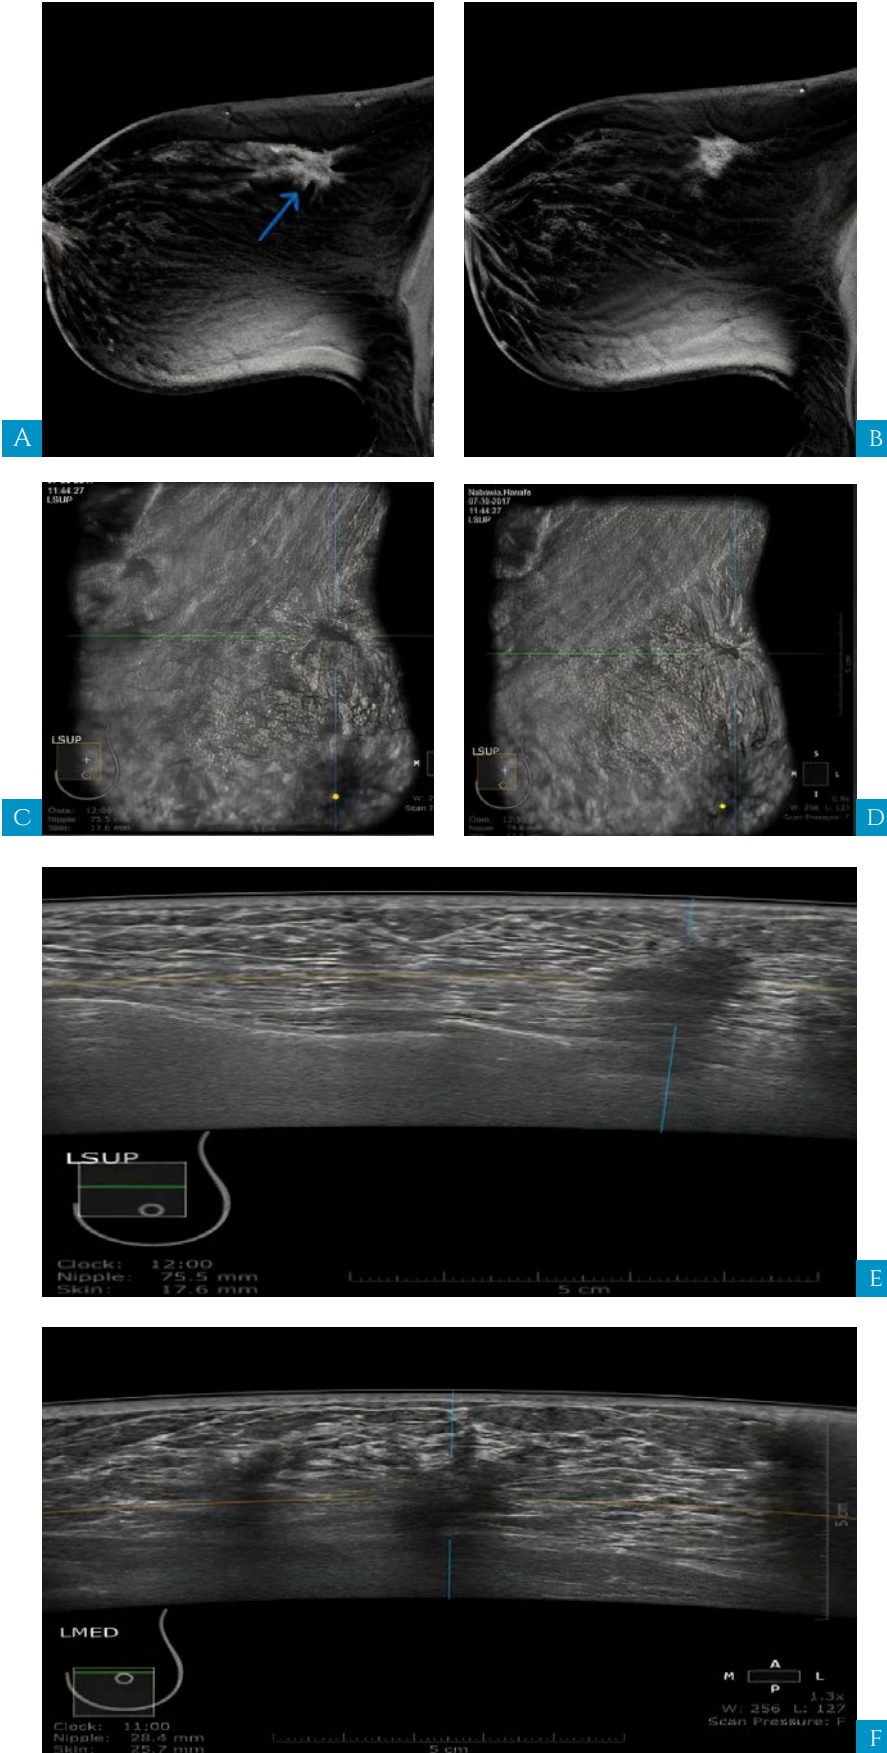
A 55 year-old female patient with a left clinically palpable lump. A & B MRI of the left breast post fat sat image axial view show two interconnecting upper central irregular speculated mass with heterogeneous enhancement (BIRAD V). C&D Automated ultrasound of the left breast coronal view show two adjacent defect with retraction phenomena with distant 74 & 75 from the nipple (BIRAD V). F&G Automated ultrasound of the left breast superior and medial view axial image show two left irregular shaped hypo-echoic mass with speculated margins, non- parallel orientation and posterior acoustic shadowing at 11 & 12 o clock.
